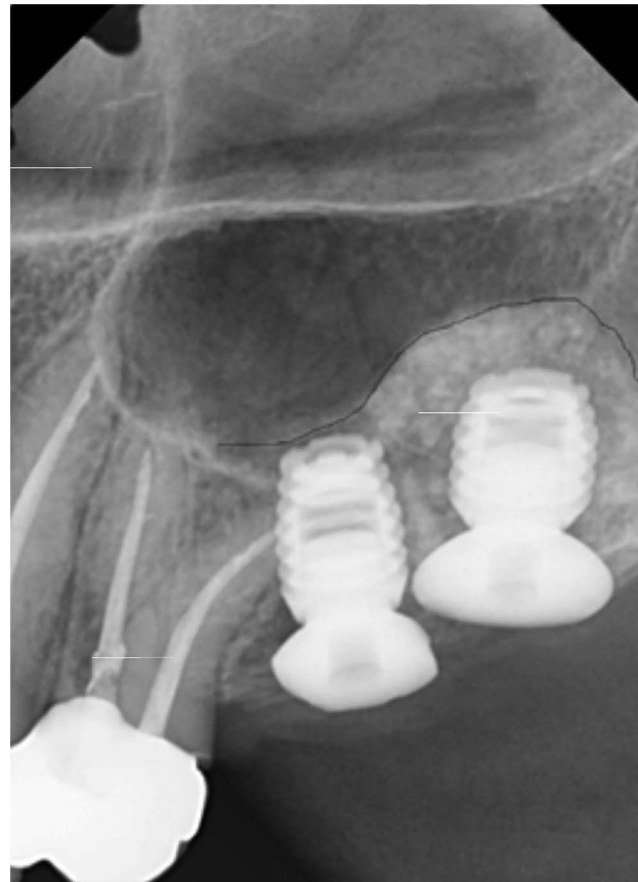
Radiograph 8 months post sinus elevation, 1 week post implant placement.
